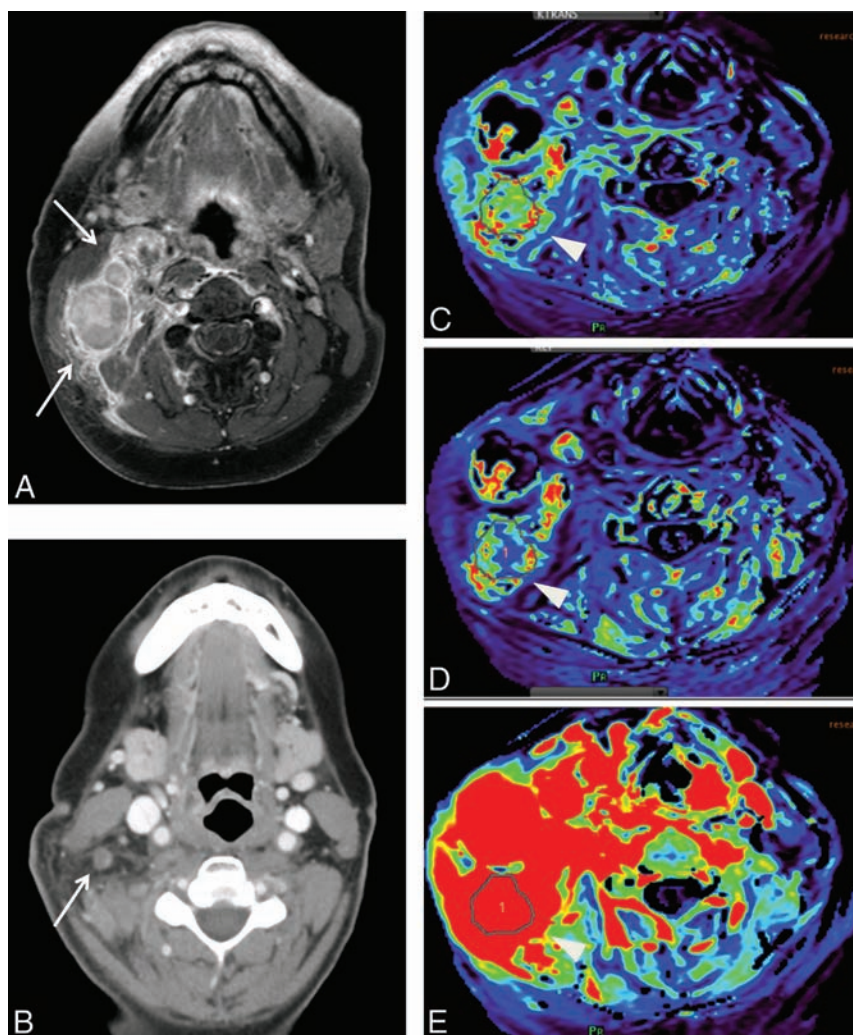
A 57-year-old male patient with T2N3bM0 undifferentiated nasopharyngeal cancer. Pre-treatment gadolinium-enhanced axial T1-weighted MR imaging of the neck demonstrates metastatic right level IIb lymph nodes (A). Parametric maps (C, D, and E) show higher volume transfer constant ($K^{trans} = 0.26/\text{min}$), K_{ep} , and area under curve, respectively. Axial contrast-enhanced neck CT at 6 months post-chemoradiation treatment demonstrates a favorable response to treatment (B).
